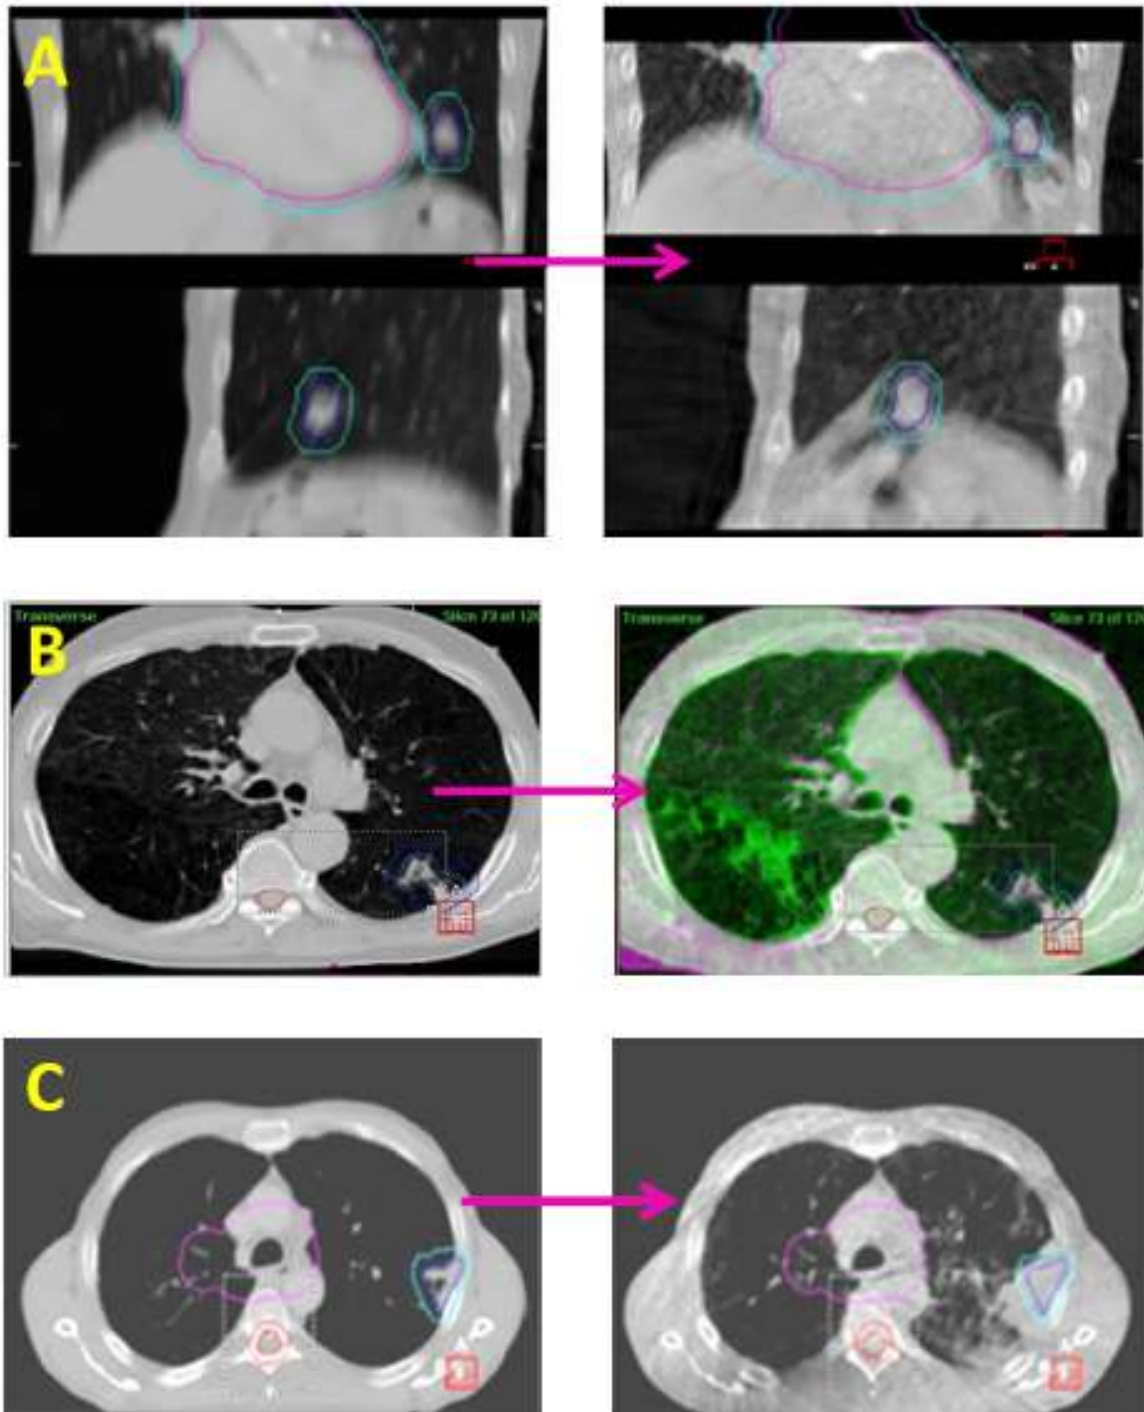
Examples of ITACs, in the left column is the RTP CT depicting the GTV and PTV contour (blue). In the right column is the CBCT. A- Coronal and sagittal projections showing tumour close to the diaphragm. The CBCT demonstrates a baseline shift scored *red* whereby the tumour has moved closer to the diaphragm causing the PTV to overlap with the small bowel. B- Axial images that show the development of infiltrative change in the contralateral lung scored *yellow*. C- Axial images of a tumour that becomes obscured by atelectasis and infiltrative change scored *red*. This ITAC makes it difficult to localise the tumour.
